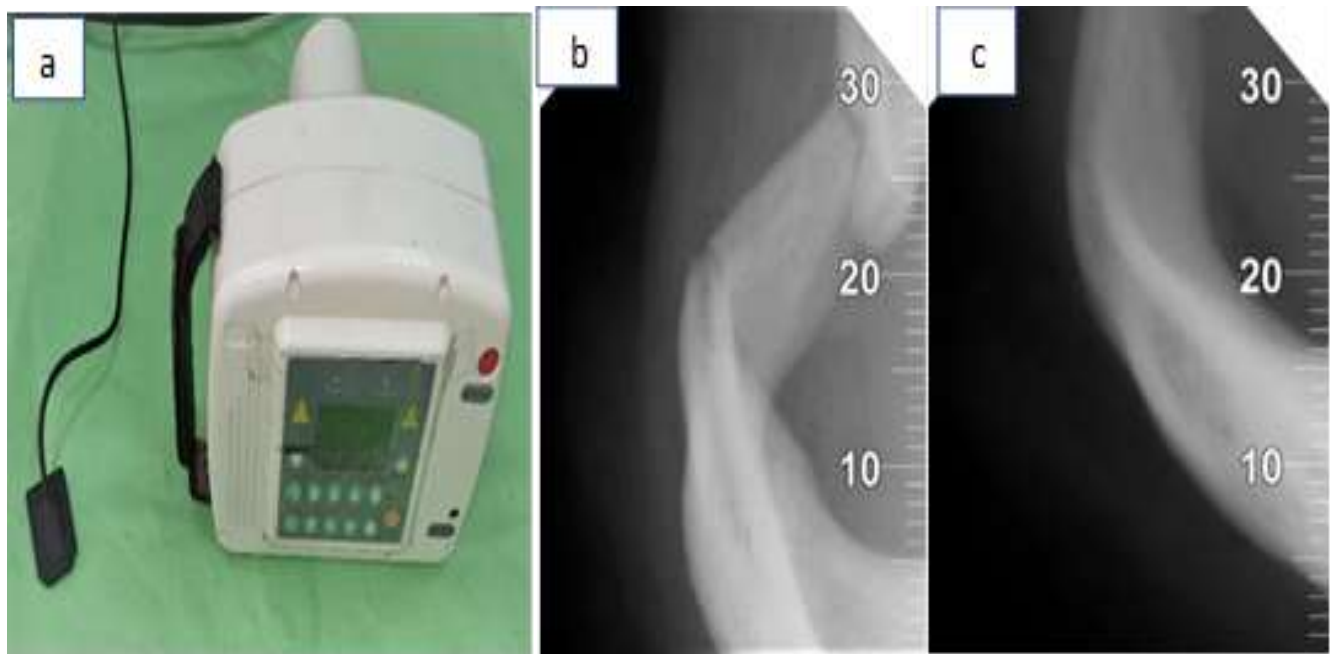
A: Portable wireless dental x-ray with the intraoral sensor. B: intraoperatively portable wireless dental x-ray reveals right side zygomatic arch fractures. C: intraoperatively portable wireless dental x-ray reveals zygomatic arch reduction.
